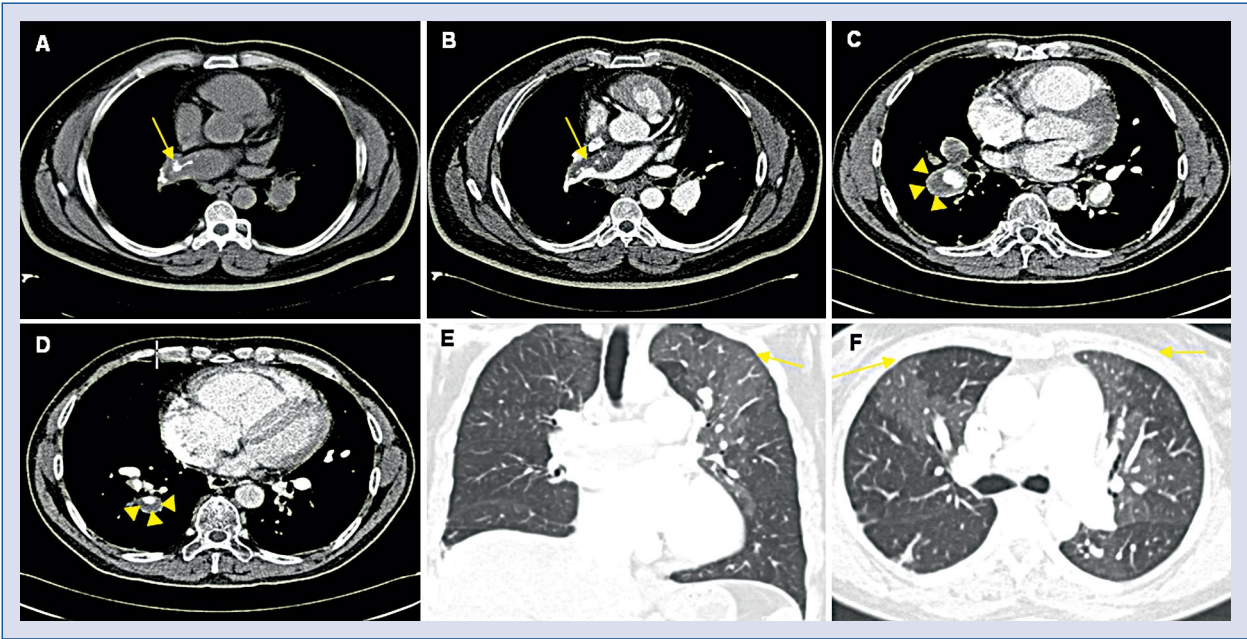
Chest computed tomography angiography (CTPA) suggesting chronic thromboembolic pulmonary hypertension. Calcific thrombi (arrows) in right pulmonary artery on pre-enhance (A), post-enhance CTPA (B), eccentric (crescentic shape) thrombi (arrow heads; C, D), and nonuniform arterial perfusion pattern and mosaic pattern of lung attenuation (E, F).
